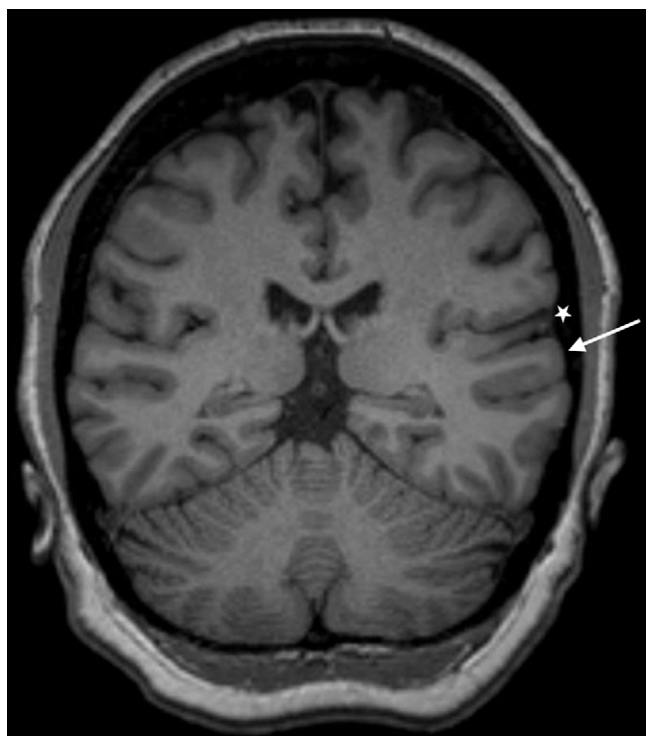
Coronal T1-weighted MRI demonstrating a region of questionable abnormal sulcation (*star*) and cortical thickening (*arrow*) in the left superior and middle temporal gyri.
